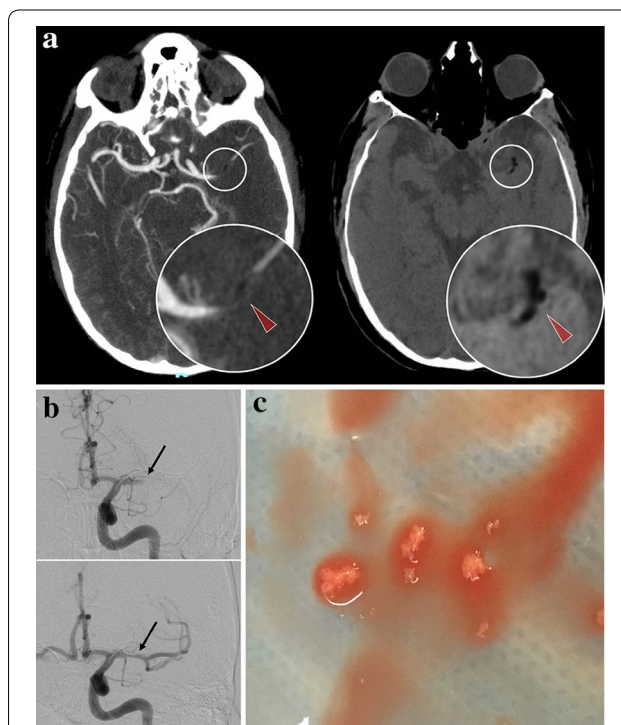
a Injected cerebral computed tomography demonstrating left middle cerebral artery occlusion (left panel) due to a negative density embolus (− 33 Hounsfield Units, red arrowheads). b Pre- and post-aspiration angiographic runs showing arterial occlusion (top, black arrow) and complete revascularization of the left middle cerebral artery (bottom, black arrow). c Macroscopic aspect of the fat embolus after thrombectomy by direct intracranial aspiration
